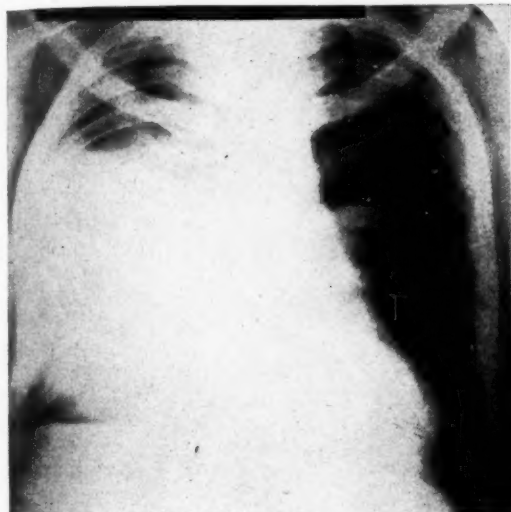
Roentgenogram of the chest of a man thirty-four years. Postmortem examination showed primary carcinoma of the right lung with metastasis to the regional lymph nodes.
